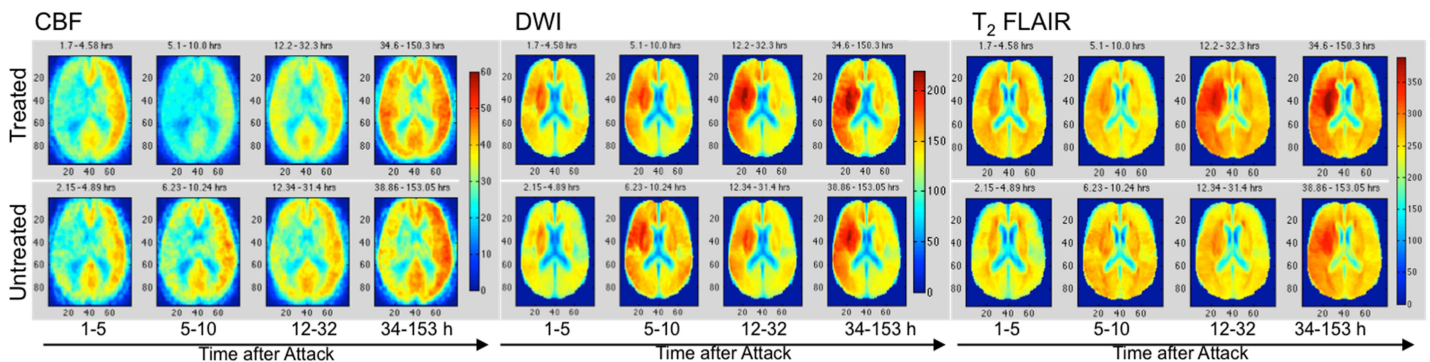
Representative moving average center-slice maps from the 4D stroke template of CBF, DWI, and FLAIR for treated (top row) and untreated (bottom row) patients over a time span of 153 hours from LKW.
